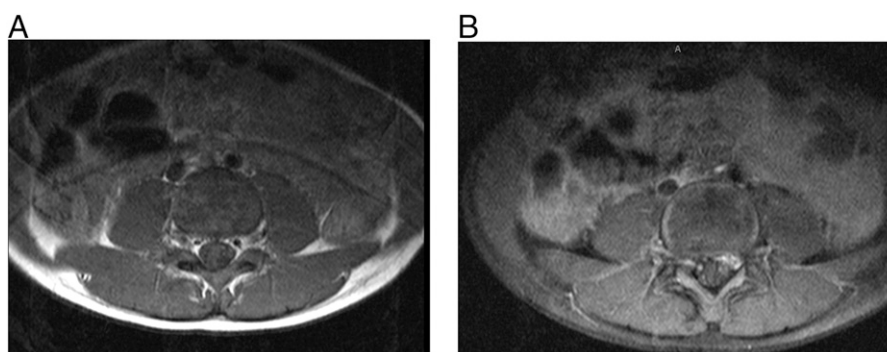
Axial T1 magnetic resonance images (MRIs) (A) without contrast and (B) with contrast. Particularly, asymmetrical enhancement of the right dorsal nerve roots versus the left can be seen in the MRI with contrast.
